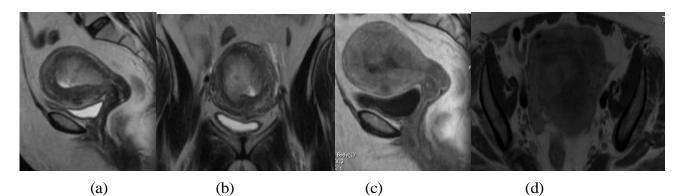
Sagittal T2 (A), Coronal T2(B), Sagittal T1 with contrast (C) and axial T1 with contrast (D) MRI images showing thickening of the endometrium reaching about 4cm in thickness with heterogeneous enhancement and small intramural uterine fibroids. No enlarged pelvic iliac lymph nodes.
